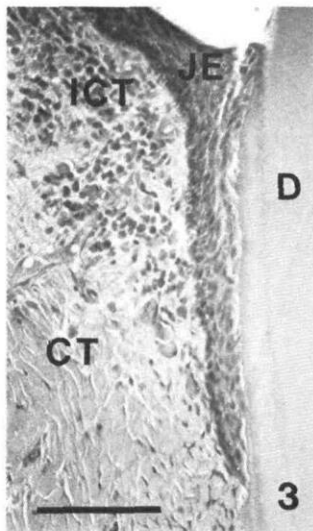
Junctional epithelium (JE) situated below the cemento-enamel junction. CT = connective tissue. ICT = infiltrated connective tissue. D = dentin. Bar represents 100 μ m.
